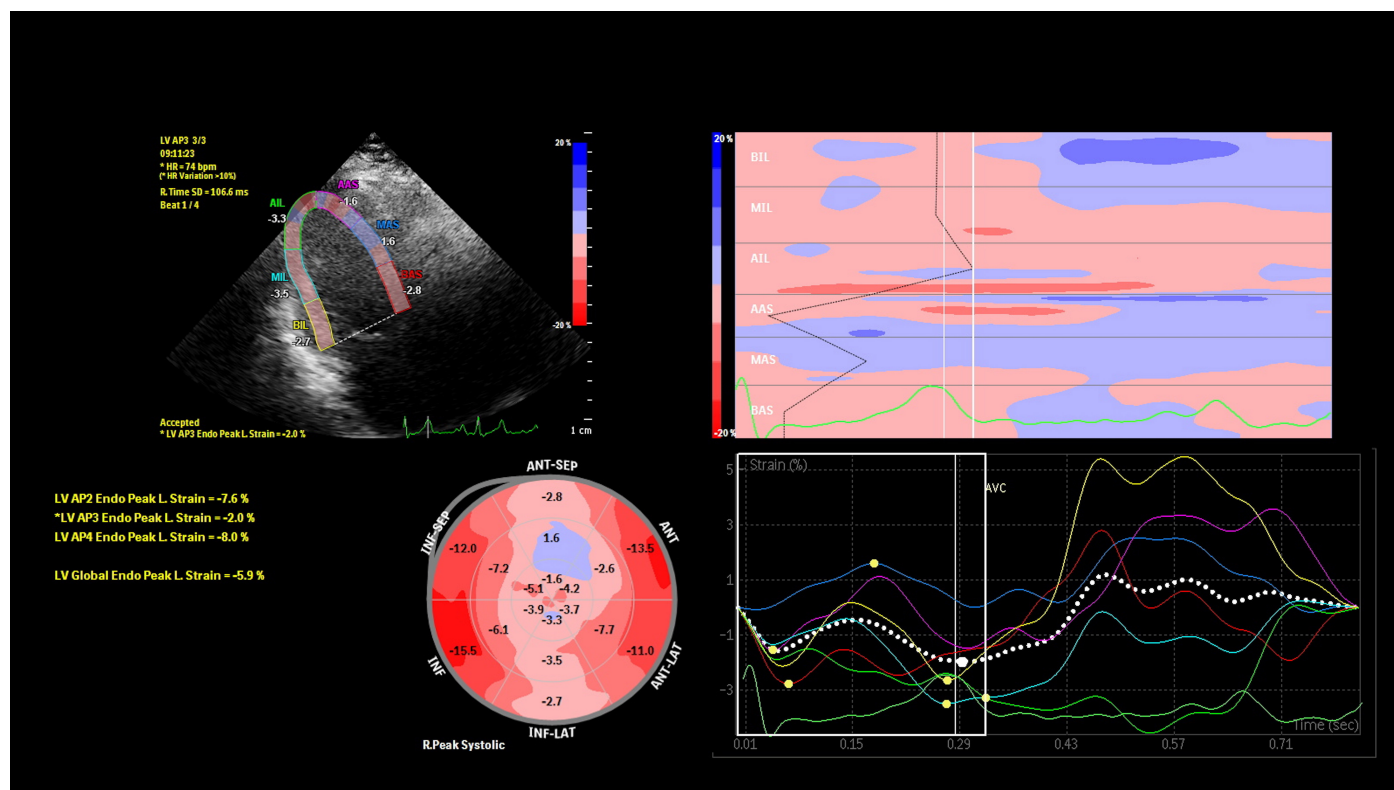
Strain echocardiography images from a patient presenting with anterior wall infarction 29 hours prior to admission. Echocardiography showed an ejection fraction of 30% and an akinetic left anterior descending artery (LAD) segments. On strain echocardiography, the patient had markedly reduced strain in the basal, mid-anterior, and apical septum as well as apical and mid-anterior segments (see bulls' eye and strain curves). The left ventricular global peak longitudinal endocardial was 5.9% and TLS of LAD territory was 3.8%. The patient had severely reduced perfusion in basal, mid-anterior, and apical septum, as well as in the mid-anterior segment involving 44-46% of left ventricular myocardium suggestive of nonviability on SPECT imaging. His angiogram revealed a subtotal proximal LAD (type 3) lesion and was managed conservatively.
